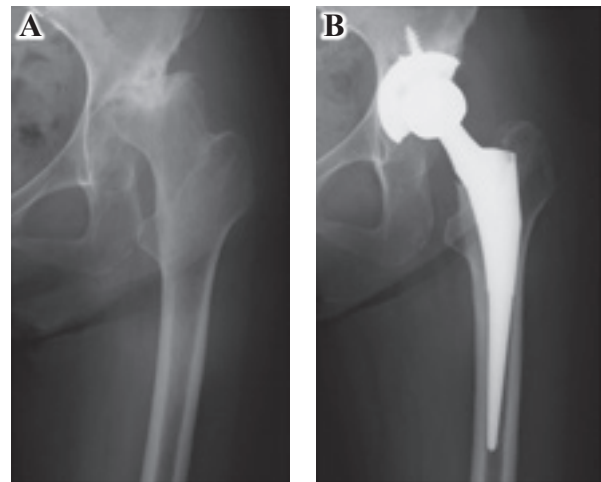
A: Preoperative radiograph, B: Radiograph when the patients complained symptoms (4 weeks after primary surgery).
